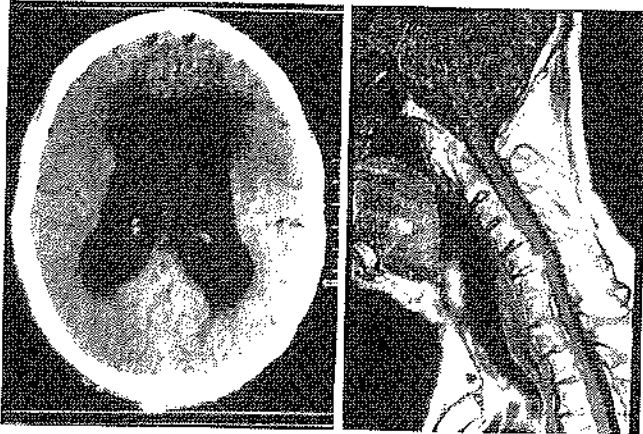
Left side: Noncontrast computed tomography (NCCT) head (axial cut) showing hydrocephalus. Right side: Magnetic resonance imaging (MRI) cervical spine (T1 sequence sagittal) showing ossified vertebral column.
